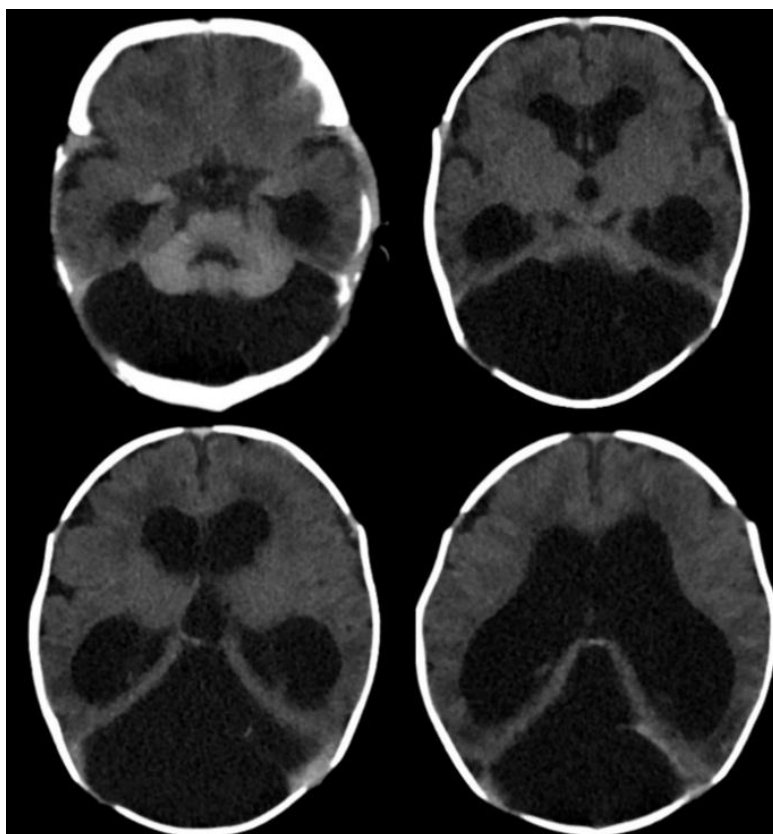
Brain CT scan showed small hyperdense area in the anterior right temporal lobe and to a lesser extent on the left side. The cerebellum and pons also appear slightly hyperdense. Mild to moderate dilatation of the lateral and third ventricles. Small cerebellum with a large cystic lesion posteriorly. The inferior vermis appears to be present
